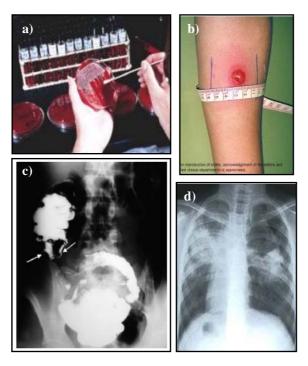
Different TB diagnostic techniques: a) sputum culture is still the reference method for the diagnosis of pulmonary TB (Source: emedicinehealth.com); b) the tuberculin skin test which should be used in combination with other diagnostic assays (Source: emedicinehealth.com); c) computed tomography (CT) of ileocecal TB which can be misdiagnosed since ileocecal TB often mimics Crohn's disease (Source: Pereira *et al.*, 2005) and d) x-rays of the lungs where TB is only detected in its progressed state (Source: emedicinehealth.com).
